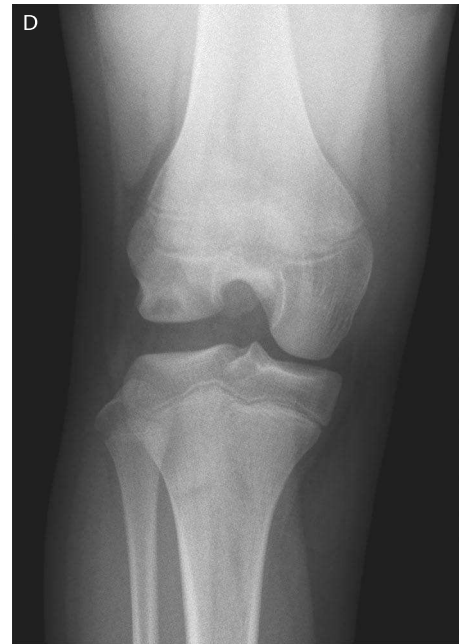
Anteroposterior non-weight-bearing plain X-ray of right knee of a 12-year-old girl, symptomatic of a lateral discoid meniscus. ‘Squaring’ of the femoral condyle, increase in the joint space, and changes (‘cupping’) in the lateral tibial plateau are visible.
